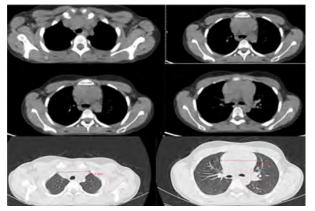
CT of thorax from December 2022- The last two slides show the image of a lung window.
